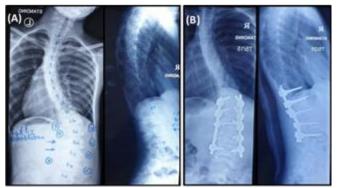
(A) Radiographs of thoracolumbar scoliosis with osteoblastoma of L2 and L3, and secondary proximal thoracic curve. (B) Postoperative radiographs after tumour resection and selective fusion T12 to L4.
